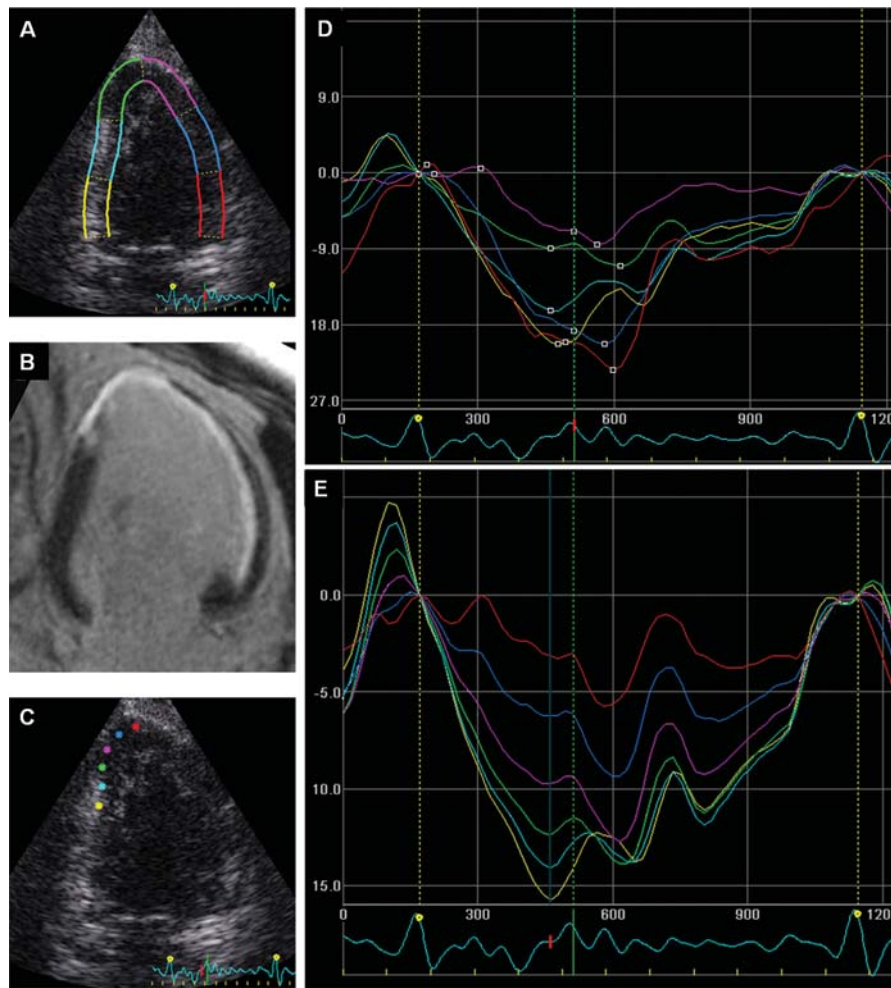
Segmental strain curves (D, E) measured by 2D STE from an apical two-chamber view (A, C). Contrast-enhanced magnetic resonance image from the same patient shows white areas of delayed enhancement in the infarcted myocardium (B). (A) Myocardial segments corresponding to the segmental strain curves in (C). The green and purple strain curves are derived from transmural infarcted segments, the red and blue curves represent subendocardial infarcted segments, and the yellow and cyan curves are from noninfarcted segments. In (C), the colored circles correspond to the strain curves (E) within one segment (apical inferior) that mainly consist of transmural infarct. The yellow curve is from the border zone of the infarct and the red is within the transmural part. Reproduced with permission from Gjesdal *et al.*¹⁹
